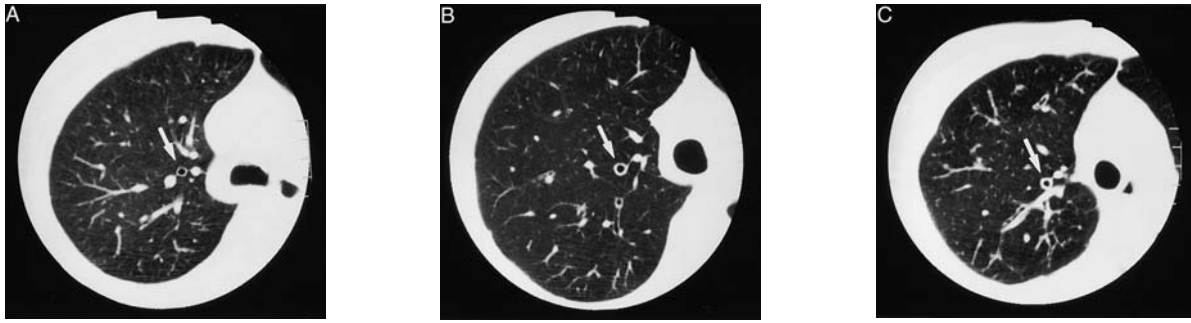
Representative CT images of (A) a control subject, (B) a patient with mild persistent asthma, and (C) a patient with severe persistent asthma. The views of the apical bronchus of the right upper lobe are indicated by arrows.
